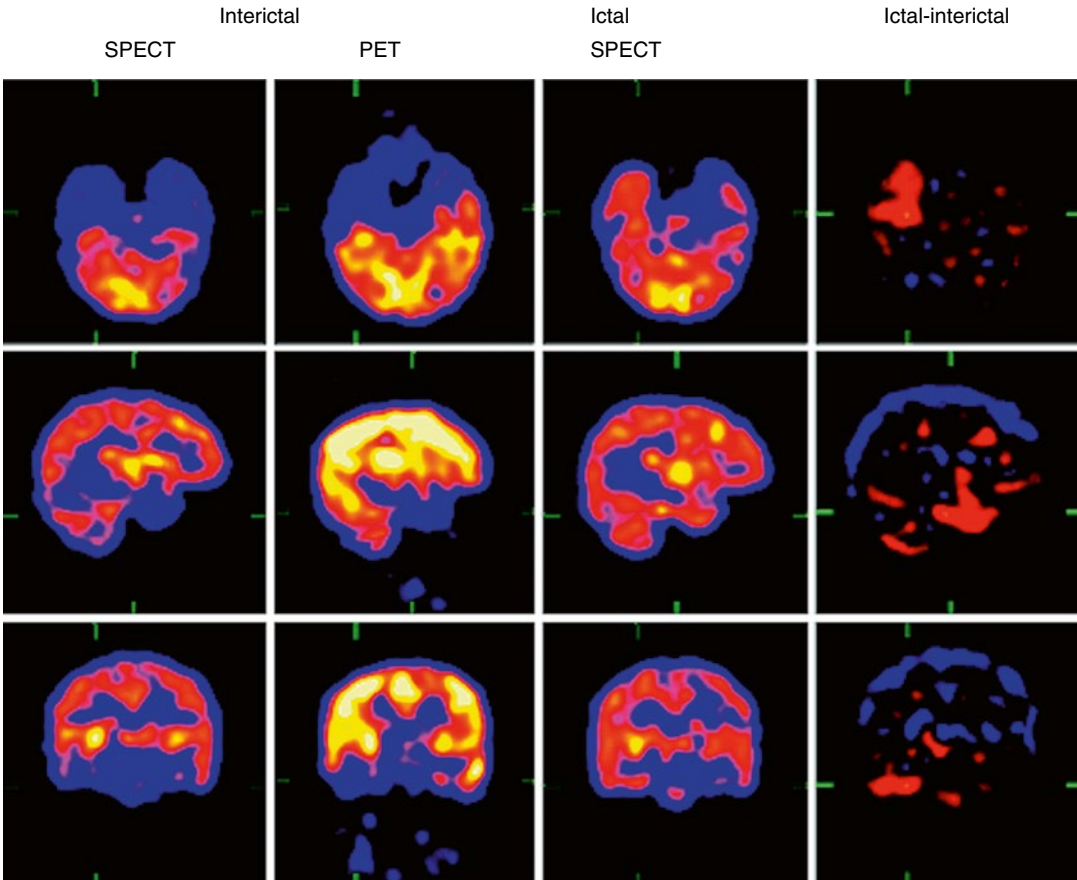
Interictal ^{18}F -FDG PET reveals significant decrease of tracer in the right temporal lobe. This is not as dramatic as on the interictal SPECT. The ictal SPECT
